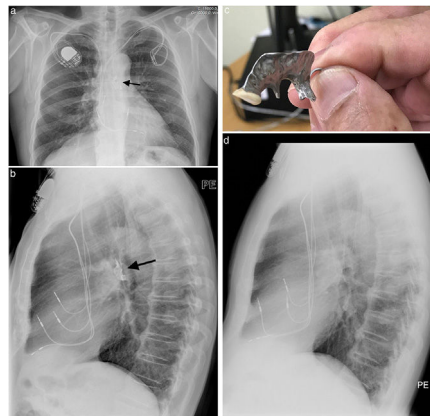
(a) Postero-anterior view of chest X-ray showing the foreign body (prosthetic teeth – black arrow) in the trachea/left main bronchus. Also, a pacemaker and the pacemaker electrodes are seen. (b) Lateral view of chest X-ray showing the foreign body (prosthetic teeth – black arrow) in the trachea/left main bronchus. Also, a pacemaker and the pacemaker electrodes are seen. (c) Prosthetic teeth hold on hand for scale. (d) Lateral view of chest X-ray showing no foreign body (prosthetic) in the trachea/left main bronchus. Also, a pacemaker and the pacemaker electrodes are seen.
